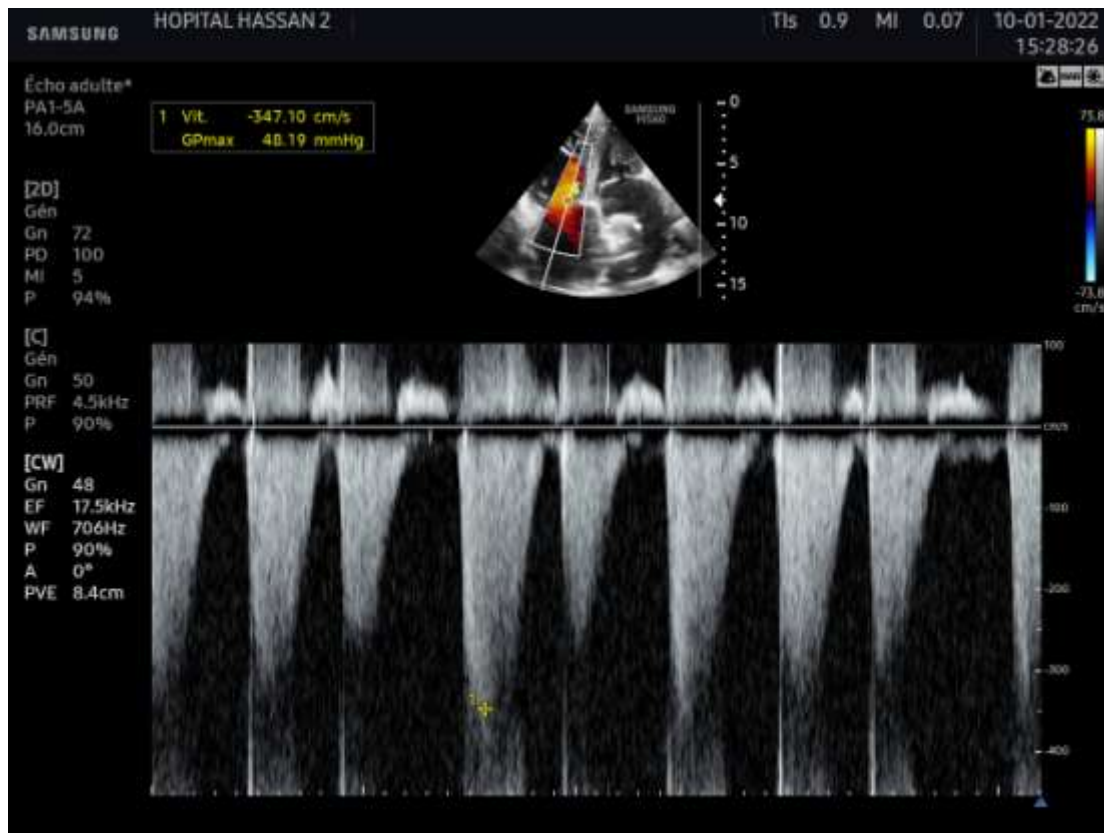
Continuous wave Doppler showing high pulmonary arterial hypertension
